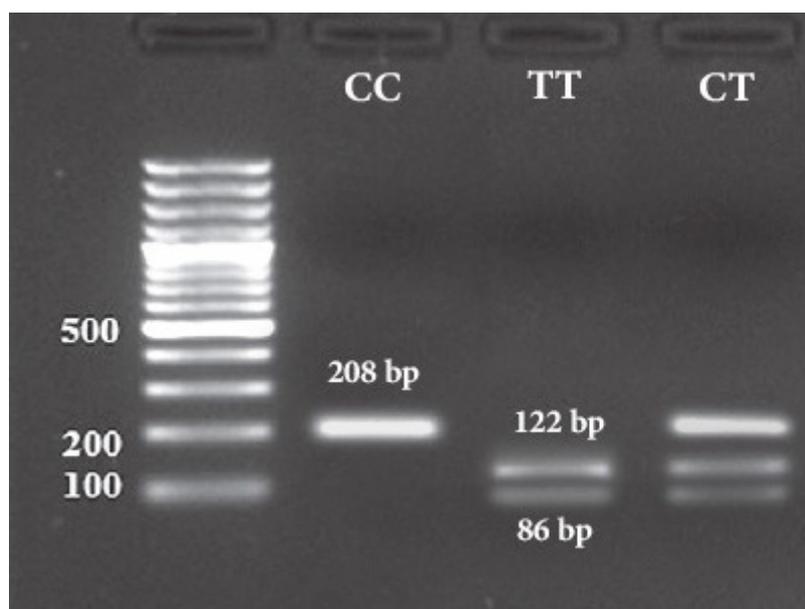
CC genotype 208 bp band, TT genotype 122+86 bp and CT heterozygote 208+122+86 bp
